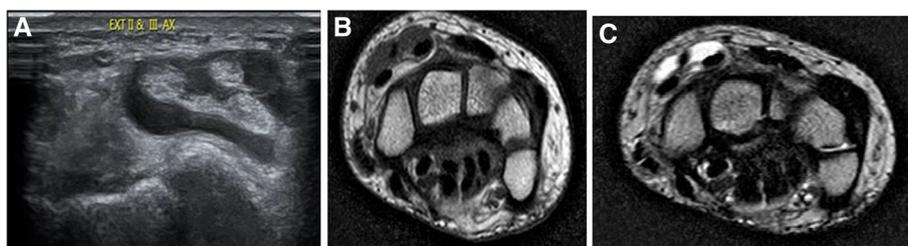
Tenosynovitis. a USG of the dorsal aspect of the wrist demonstrates fluid collection around the second and third extensor compartments. b, c Axial T1WI and axial T2WI MRI of the wrist demonstrates fluid collection around the second and third extensor compartments
